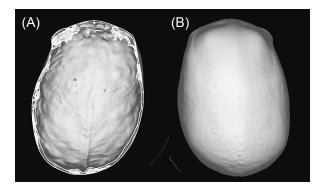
3D reconstruction CT image of calvaria. (A) Internal surface, (B) External surface.
